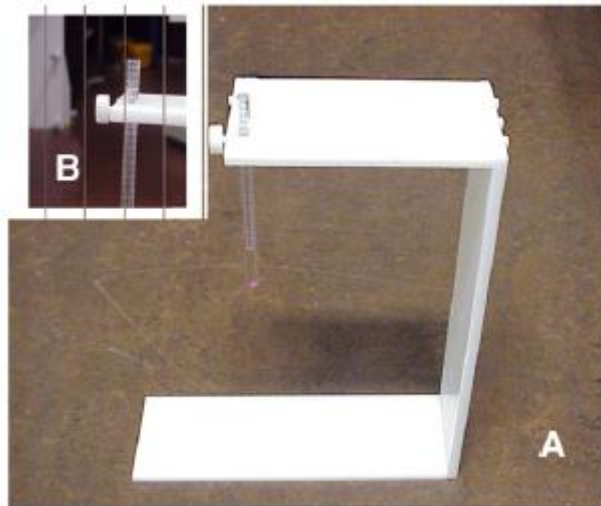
(A) The “breathing stick” that was placed on the skin of the patient outside the radiation fields in the epigastric area during breath hold and (B) an integrated ruler. The contact point of the tip of the ruler was marked by a dot on the skin during the third computed tomography scan in voluntary moderately deep inspiration breath hold (vmDIBH). During treatment, the radiation technician could check visually, and the patient could feel, whether the tip of the stick made contact at the dot on the skin, ensuring a correct breath hold.
